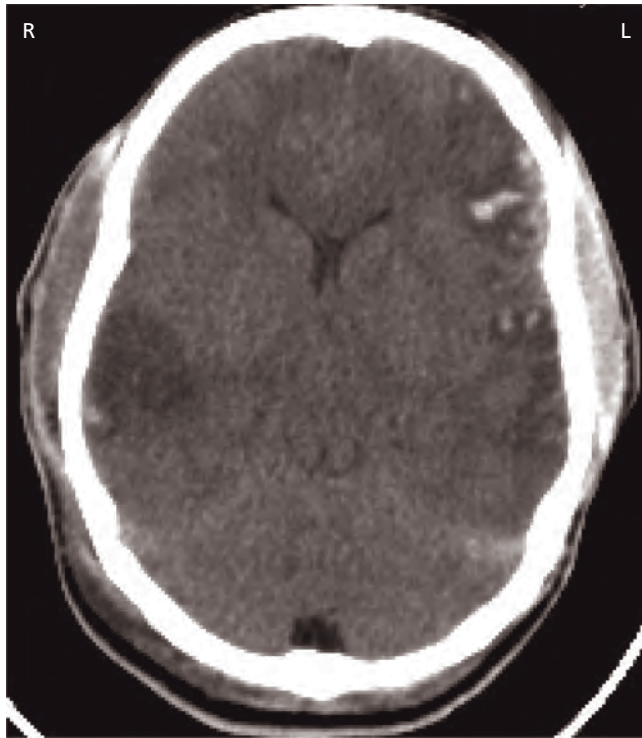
CT scan of patient with traumatic brain injury (TBI) showing extensive left temporal contusion and laceration with contrecoup injury in right parietal region.
